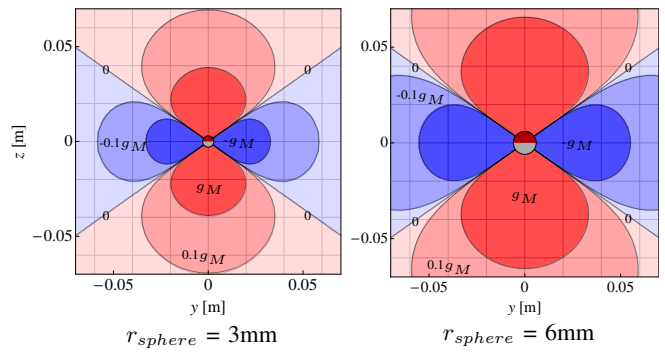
Contour lines show the force component radially outward from a sphere at (0, 0) on an identical sphere in an MRI. The magnetic field is symmetric about the z -axis.
